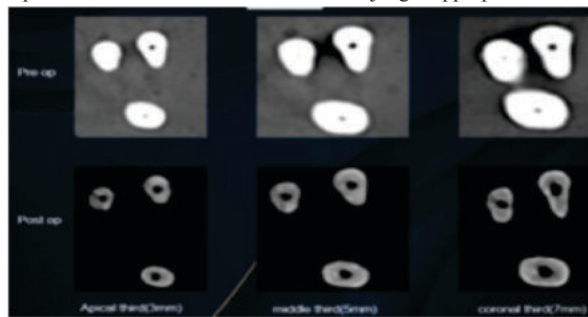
CBCT analysis (WOG)
